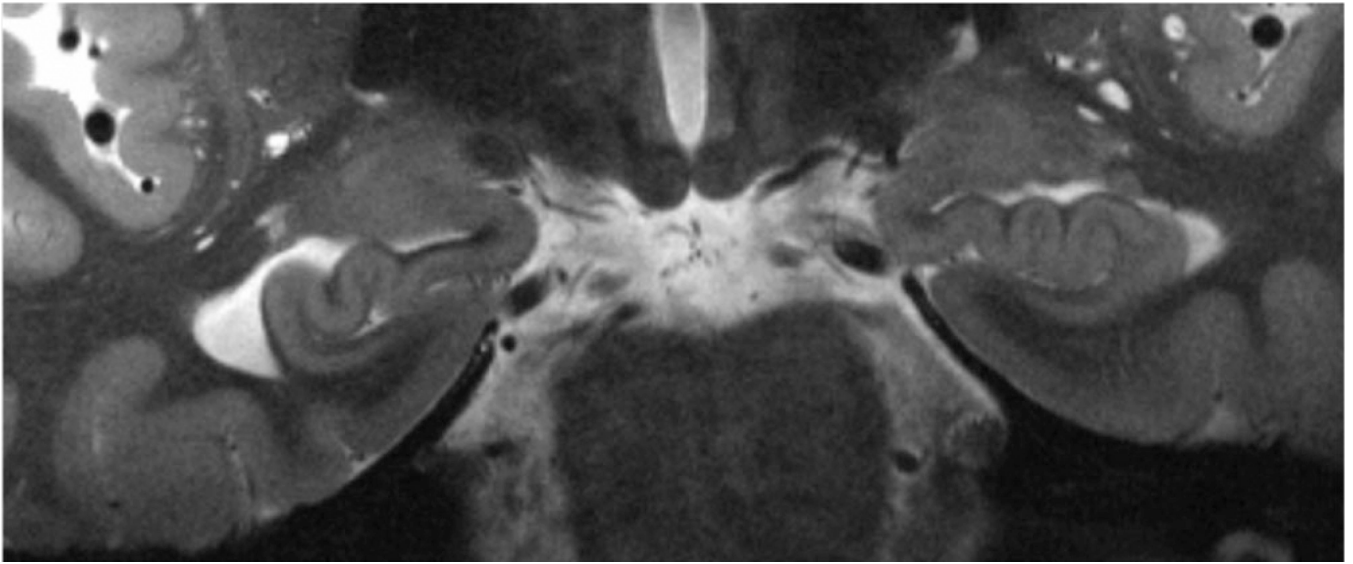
T₂-weighted MR images of the head of hippocampus obtained at 7 T in a coronal slice, from a control subject (31-year-old male). Adapted from [160].
